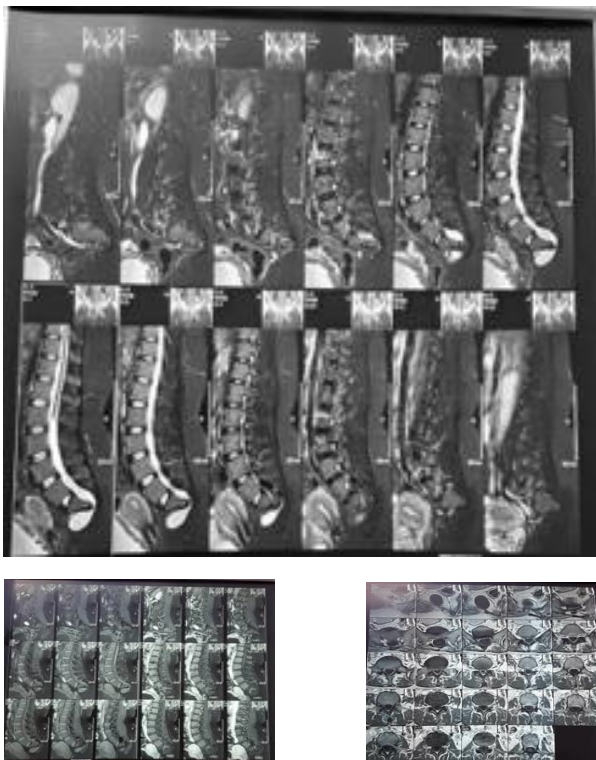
A, B MRI sagittal view of the lumbosacral spine T1 and T2 showing an intradural mass hypointense in T1 and hyperintense in T2 extending from L2 to the sacrum and turning anteriorly to the. Partial agenesis of the sacrum is also evident. C: MRI axial view showing cystic cavity in the sacral spine extending anteriorly in the pelvis through a widened sacral foramen.
